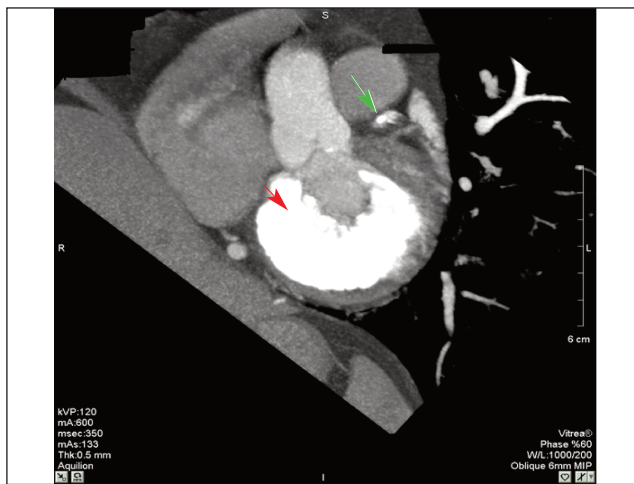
b: Cardiac computed tomography, short axis view at the level of the mitral annulus shows dense curvilinear calcification (Red arrow). Incidentally there is evidence of calcific coronary artery disease (Green arrow).
